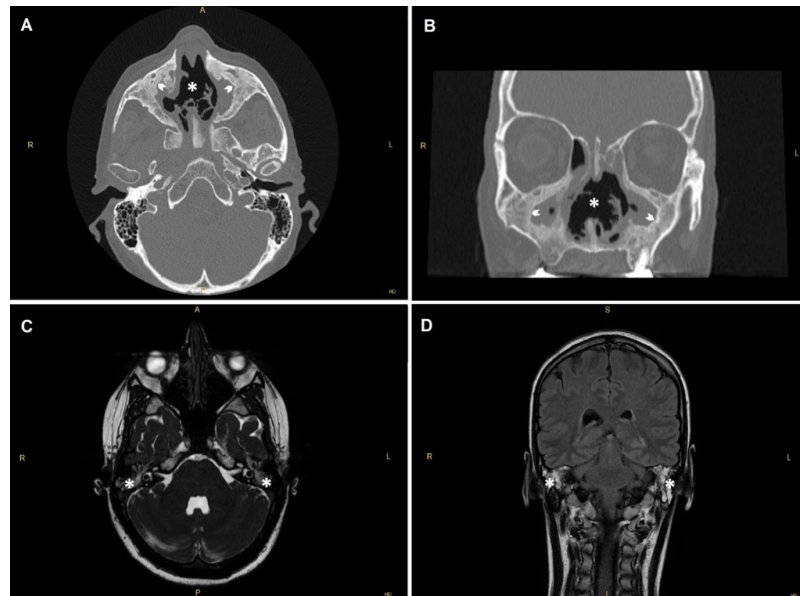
Radiological aspect of chronic rhinosinusitis, anterior septal perforation (asterisks), and maxillary sinus osteitis (arrowhead) in a patient diagnosed with granulomatosis with polyangiitis [CT scan, axial (A) and frontal (B) views]. T2-weighted MRI axial scan (C) and fluid attenuated inversion recovery (FLAIR) coronal scan (D) showing diffuse hyperintense opacification of the middle ear and mastoid cells in bilateral mastoiditis (asterisks).
